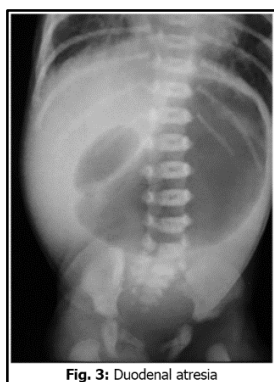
A plain X-ray supine abdomen shows ‘double bubble sign’ with paucity of bowel gas distally.
